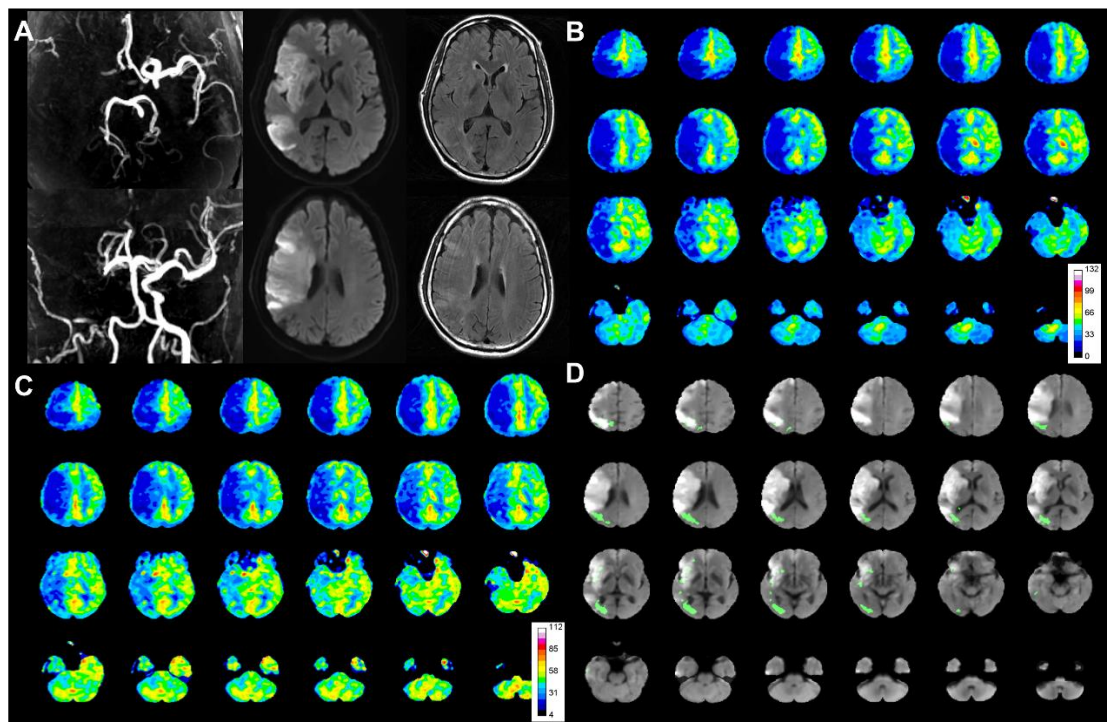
Figure shows a 66-year-old male patient with acute right internal carotid and middle cerebral artery occlusion. Diffusion-weighted imaging (DWI) demonstrates territorial infarction with a volume of 182.74 mL (A). Territorial hypoperfusion can be observed on cerebral blood flow maps on arterial spin labeling with a post-labeling delay (PLD) of 1500ms (B). Delayed inflow in the territory is visible on cerebral blood flow maps from PLD of 1500 ms to 2500 ms (C). The volume of collateral perfusion as overlaid green mask on DWI is 31.72 mL (D). The collateral-core ratio was measured as 0.17. The patient developed an unfavorable functional outcome (3-month mRS score is 4).
